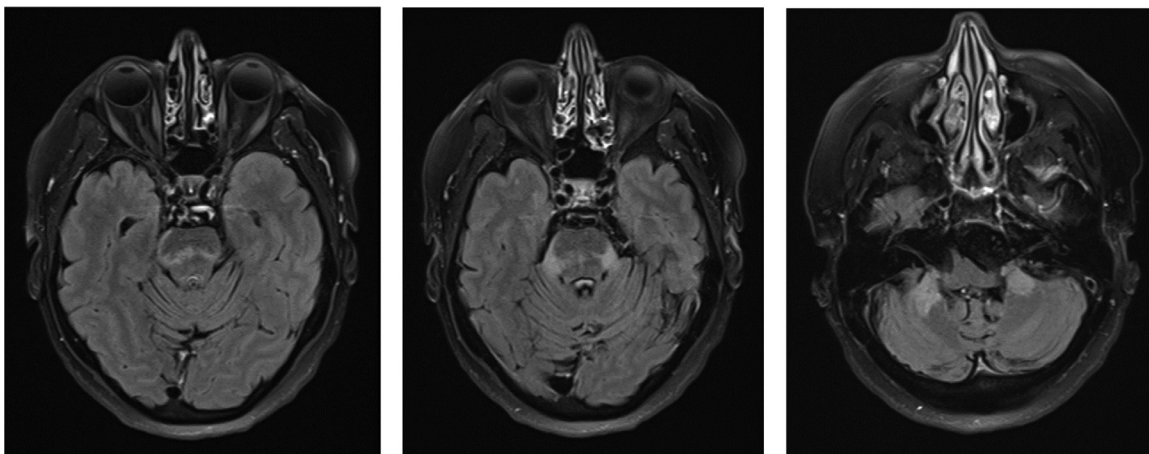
MRI brain three months post-treatment. T2 FLAIR sequences demonstrating radiological improvement in the previously known hyperintense areas.
